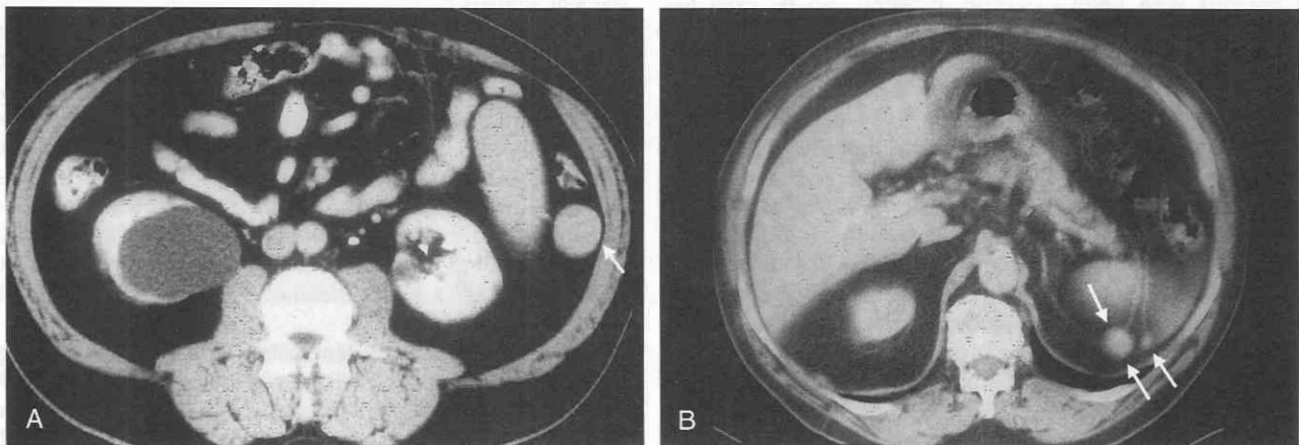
CT scans showing accessory spleens in unusual locations. A, Accessory spleen (arrow) lateral to the spleen's lower pole. B, Accessory spleens (arrows) inferior and lateral to the spleen's lower pole.
